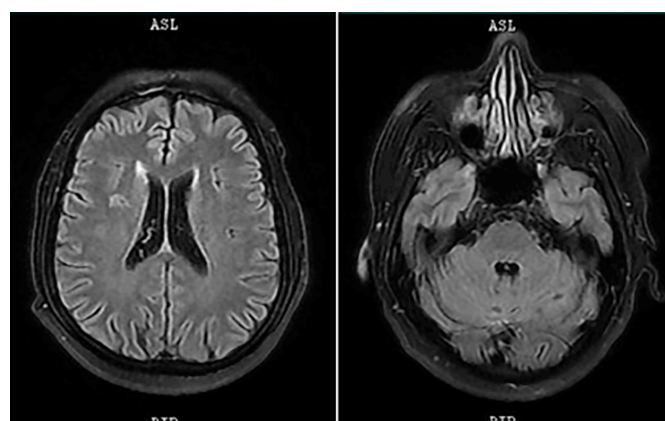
MRI brain (T2 FLAIR) showing resolved cerebral abscess.
